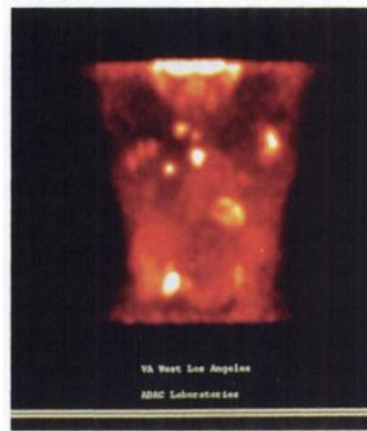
Convergent PET and SPECT. A dual detector (SPECT) FDG study of a patient with metastatic cancer.
